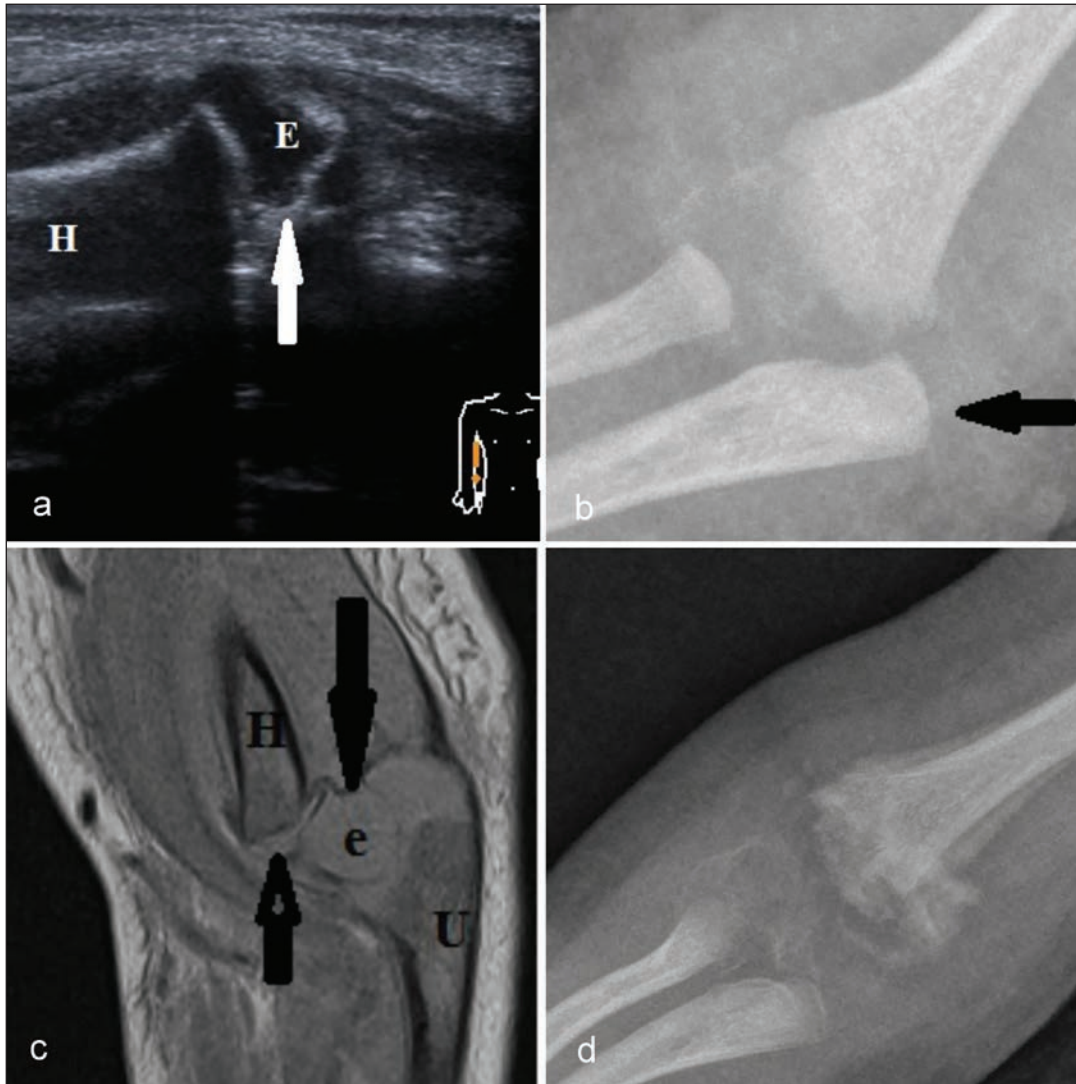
a) Elbow ultrasonography: dislocation of the humeral distal epiphysis (white arrow), H-humerus, E- humeral epiphysis. b) Radiogram of the painful elbow: malalignment of bones in the elbow joint (black arrow). c) Magnetic resonance of the elbow (PD TSE sagittal sequence): humeral epiphysis (e) dislocation from growth plate (empty arrow) is clearly seen. H=humeral, U=ulna. d) Follow up radiogram after 10 day immobilization.
